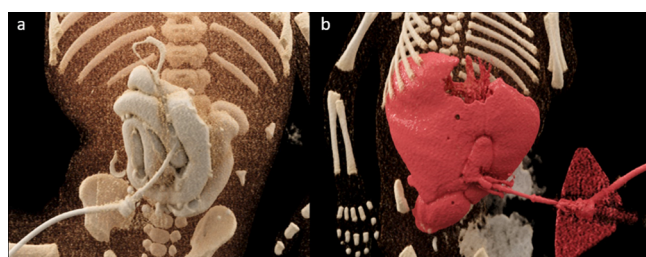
Example of failures: CT angiography image using the Cinematic Rendering Technique (CRT) showing bowel injection in formalized fetus (A) and abdominal extravasation (B).
